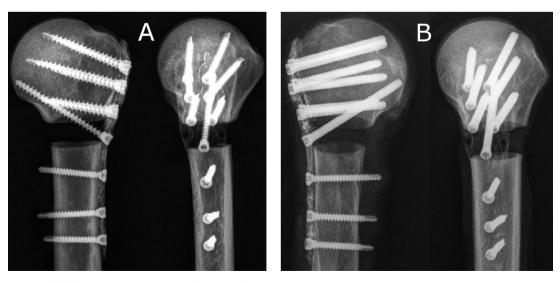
X-rays in two planes of a left humerus after osteotomy and fixation with the CF-PEEK plate and seven conventional. A: 4.0 mm cancellous locking screws in the humeral head. B: Newly developed 4.0 mm locking bolts in the humeral head.
